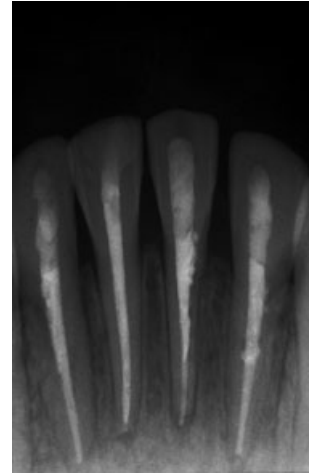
Radiograph taken 15 months after trauma and completion of root canal treatment in all lower incisors.
